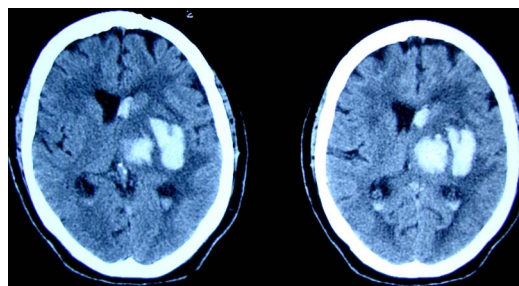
Urgent, non-contrast, axial brain CT scan of the patient. There are two left-sided hyperdense lesions which are indicative of acute intracerebral haemorrhages.
